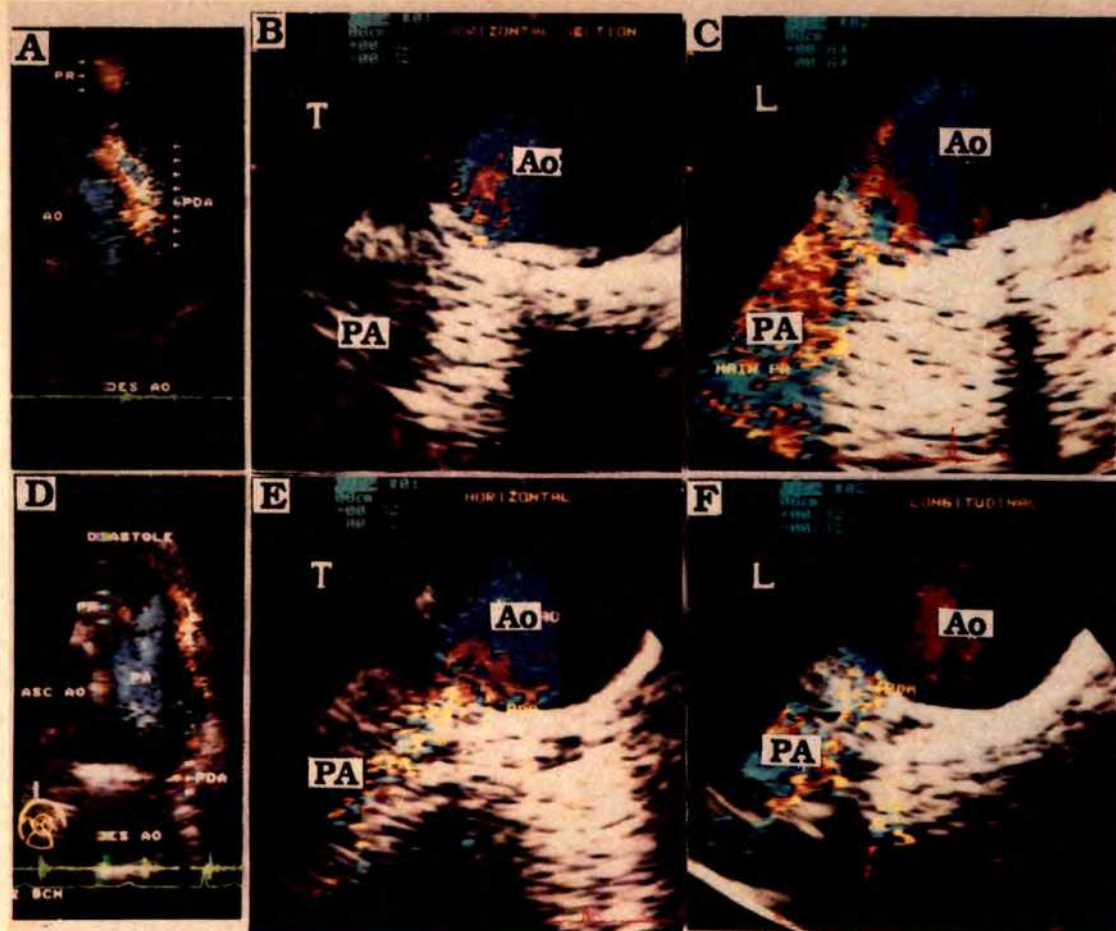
Transthoracic (A and D) and transesophageal (transverse [B and E] and longitudinal [C and F] scans) echocardiograms from 2 patients with patent ductus arteriosus (PDA). In patient 7 (A to C), shunt flow could not be visualized in the distal pulmonary trunk with transthoracic echocardiography (A), and shunt flow was visualized from the aorta (AO) through the ductus into the pulmonary artery (PA) on the same cross section only with transesophageal longitudinal scan (C). In patient 1 (D to F), shunt flow was visualized from the distal to the proximal pulmonary trunk with transthoracic echocardiography (D), and shunt flow was visualized from the aorta through the ductus into the pulmonary artery on the same cross section with both transesophageal transverse (E) and longitudinal (F) scans. ASC = ascending; DES = descending; L = longitudinal scan; T = transverse scan.
